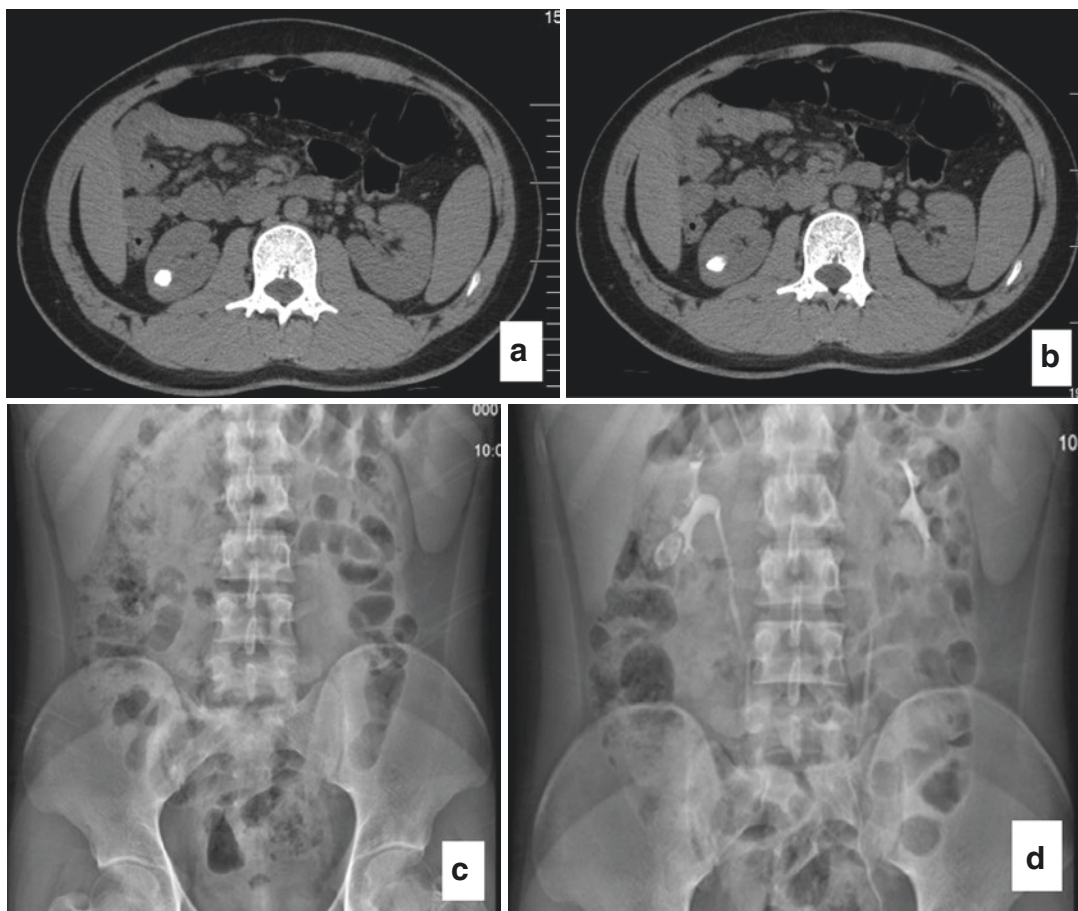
(a, b) CT scan images from a patient with a right kidney calyceal diverticulum occupied by a stone. (c, d) Intravenous pyelogram images of a patient with a
